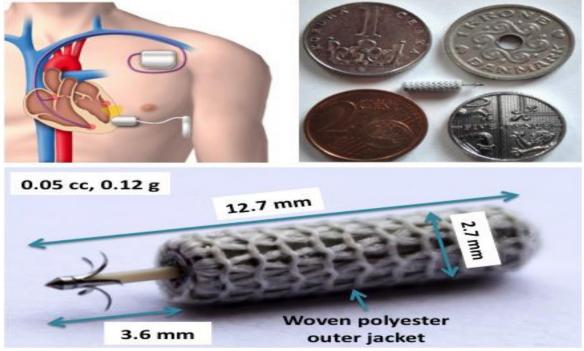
Overview of the system for LV endocardial lead less pacing (WiCS-LV System), Ultrasonic Receiver (Upper right corner and lower photo)
